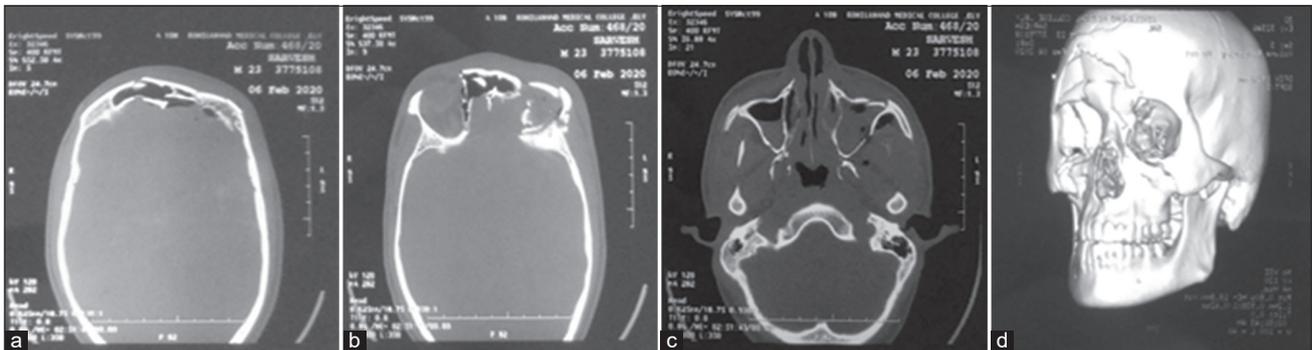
(a) Axial section of computed tomography (CT) scan showing comminuted fracture of the anterior and posterior table of the frontal bone (b) Axial section of CT scan showing fracture of the lateral wall of the orbit (c) Axial section of the patient showing right and left Zygomatico-complex # (d) Three-dimensional section of the face showing comminuted frontal bone fracture
